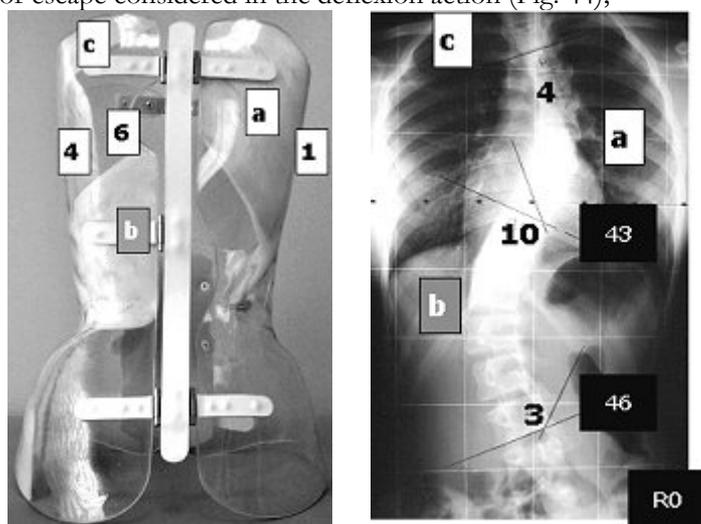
Action of derotation according to SPoRT concept for thoracic scoliosis in the posterior-anterior and radiographic views.
